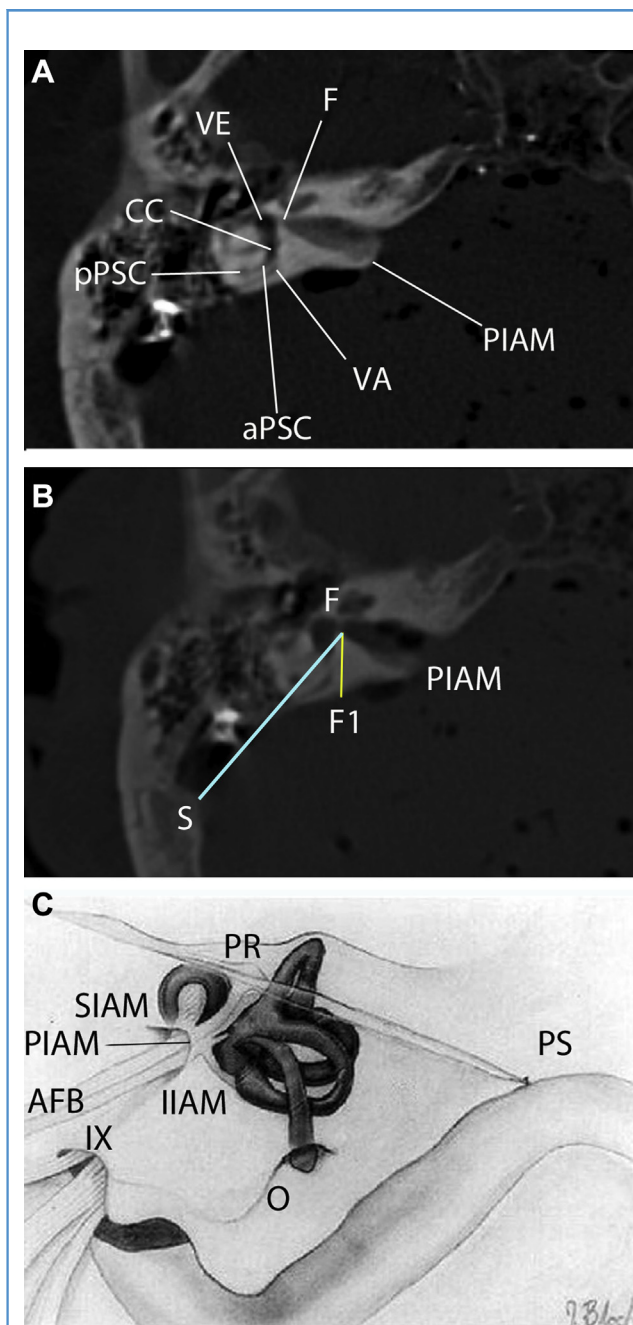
Computed tomography scan and anatomic landmarks (A) Landmarks identified and digitized on computed tomography scan. (B) The yellow line, going from the fundus to the petrous surface parallel to the vestibule, represents our safety line. Its intersection with the pyramid surface is the point F1; the light blue line is the sigmoid-fundus line (see the Methods section). (C) Landmarks identified and digitized on petrous bone surface. AFB, acoustic-facial bundle; aPSC, anterior part of the posterior semicircular canal; CC, common crus; F, fundus of IAM; F1, projection of the fundus on the petrous bone surface along the safety line; IIAM, inferior lip of internal acoustic meatus; IX, entry point of IX cranial nerve in the jugular foramen; O, opercule of endolymphatic sac; PIAM, posterior lip of internal acoustic meatus; pPSC, posterior part of the posterior semicircular canal; PR, petrous ridge; PS, petrosigmoid intersection; S, sigmoid; SIAM, superior lip of internal acoustic meatus; VA, vestibular aqueduct; VE, vestibule. Adapted from Ammirati et al.²⁶ with permission from the American Association of Neurological Surgeons.
